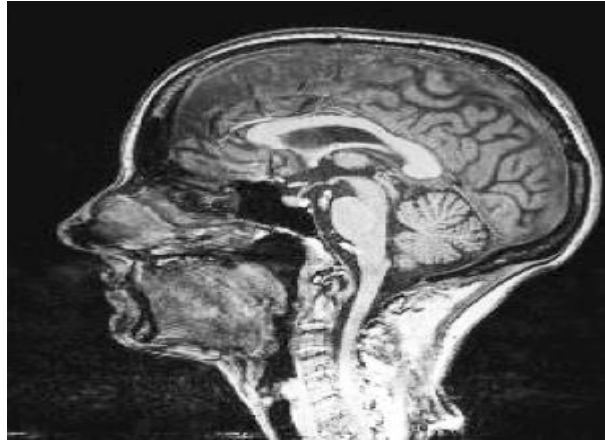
Brain image obtained using MRI technique [8]
